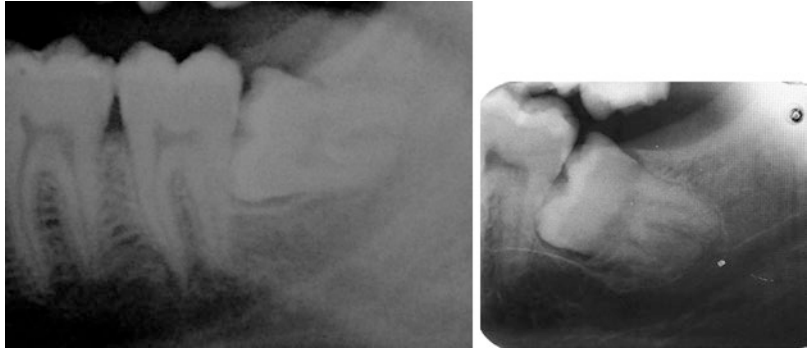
On the left a periapical radiograph of a missing person; on the right the periapical radiograph of an unknown corpse showing the same morphological
